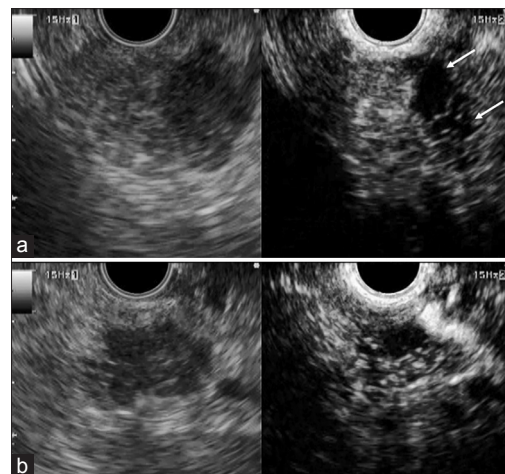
A case of pancreatic cancer. (a) Endoscopic ultrasound images before chemotherapy. Conventional endoscopic ultrasound (left image) shows low-echoic mass in the pancreatic head. Contrast-enhanced harmonic endoscopic ultrasound (right image) is showing the avascular area in the tumor (arrows). (b) Endoscopic ultrasound images after chemotherapy. Avascular area decreased on contrast-enhanced harmonic endoscopic ultrasound (right image)
